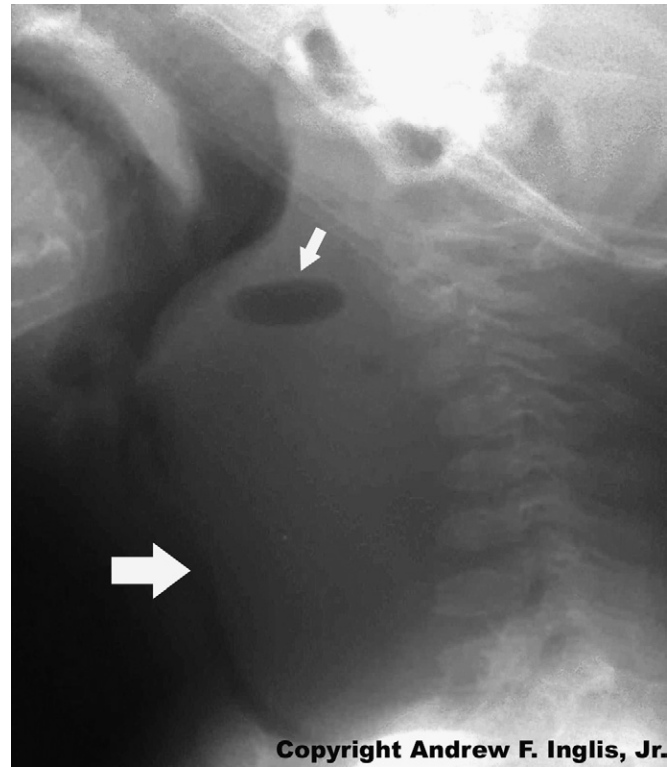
Lateral radiograph of the neck of a patient with retropharyngeal abscess. Note the thickening of the prevertebral soft tissue and the radiolucent area caused by the presence of air in the tissue. (Copyright Andrew F. Inglis Jr.)
